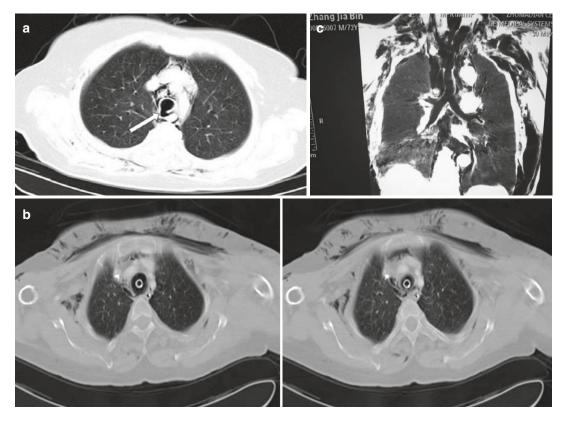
CT examination of the tracheal rupture
